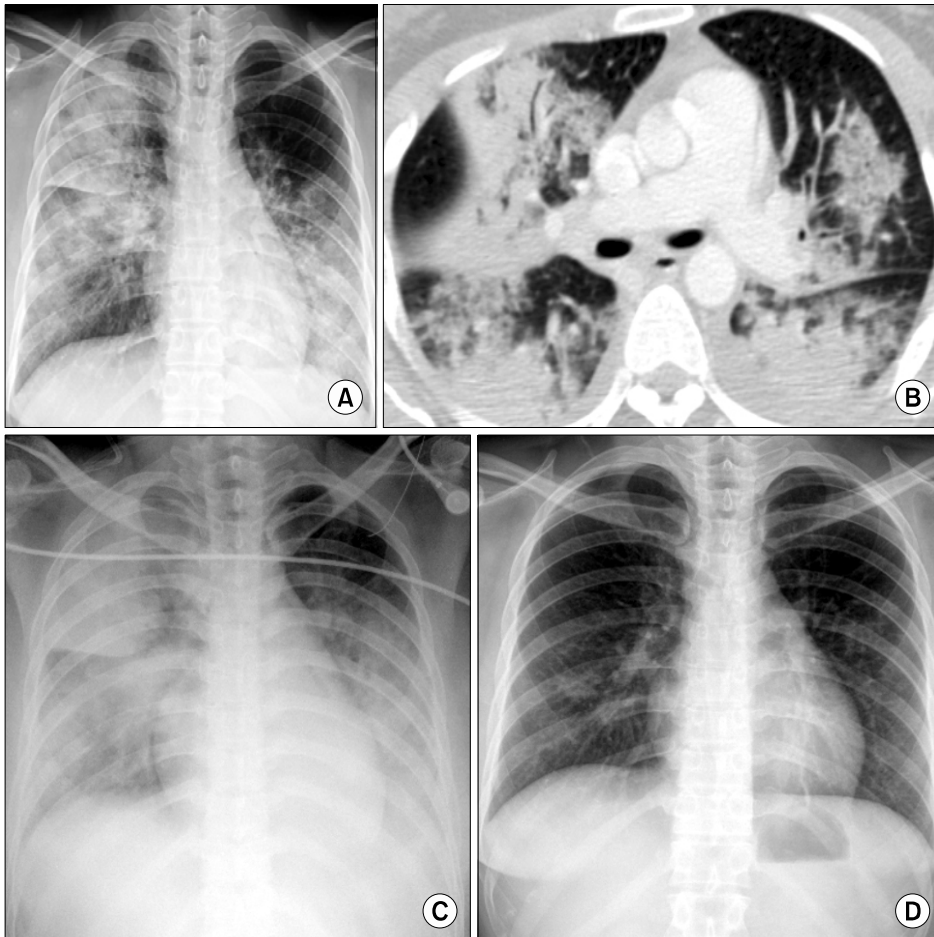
A 29-year-old woman with *M. pneumoniae* pneumonia. Chest radiograph at admission reveals bilateral, patch and lobar consolidation in right upper and left lower lung field (A). Chest CT scan, 2 days later, shows multi-focal consolidation (B). Follow up chest radiograph, 3 days later, shows more extensive bilateral consolidation (C). Follow up chest radiograph, 9 days later, shows nearly complete resolution (D).
